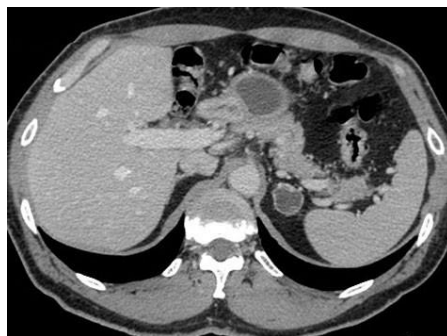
Axial contrast-enhanced CT image showing a rounded lesion interpreted as the upper portion of the left adrenal gland with sharp edges and weak parietal enhancement.
